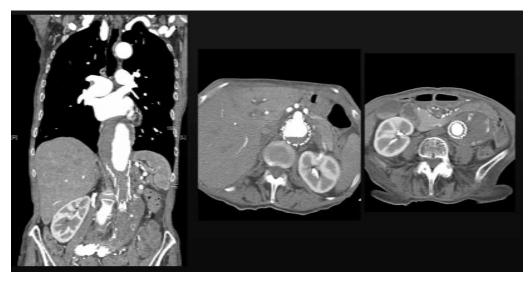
CT of a fragile octogenarian patient with a branched endovascular repair with a Zenith (Cook Incorporated, Bloomington, IN) device. Left panel shows asymptomatic subsequent 6-cm thoracic aneurysm above bare topstent component. Middle panel shows patent branch grafts. Right panel shows large excluded abdominal aneurysm. Observation is recommended.
